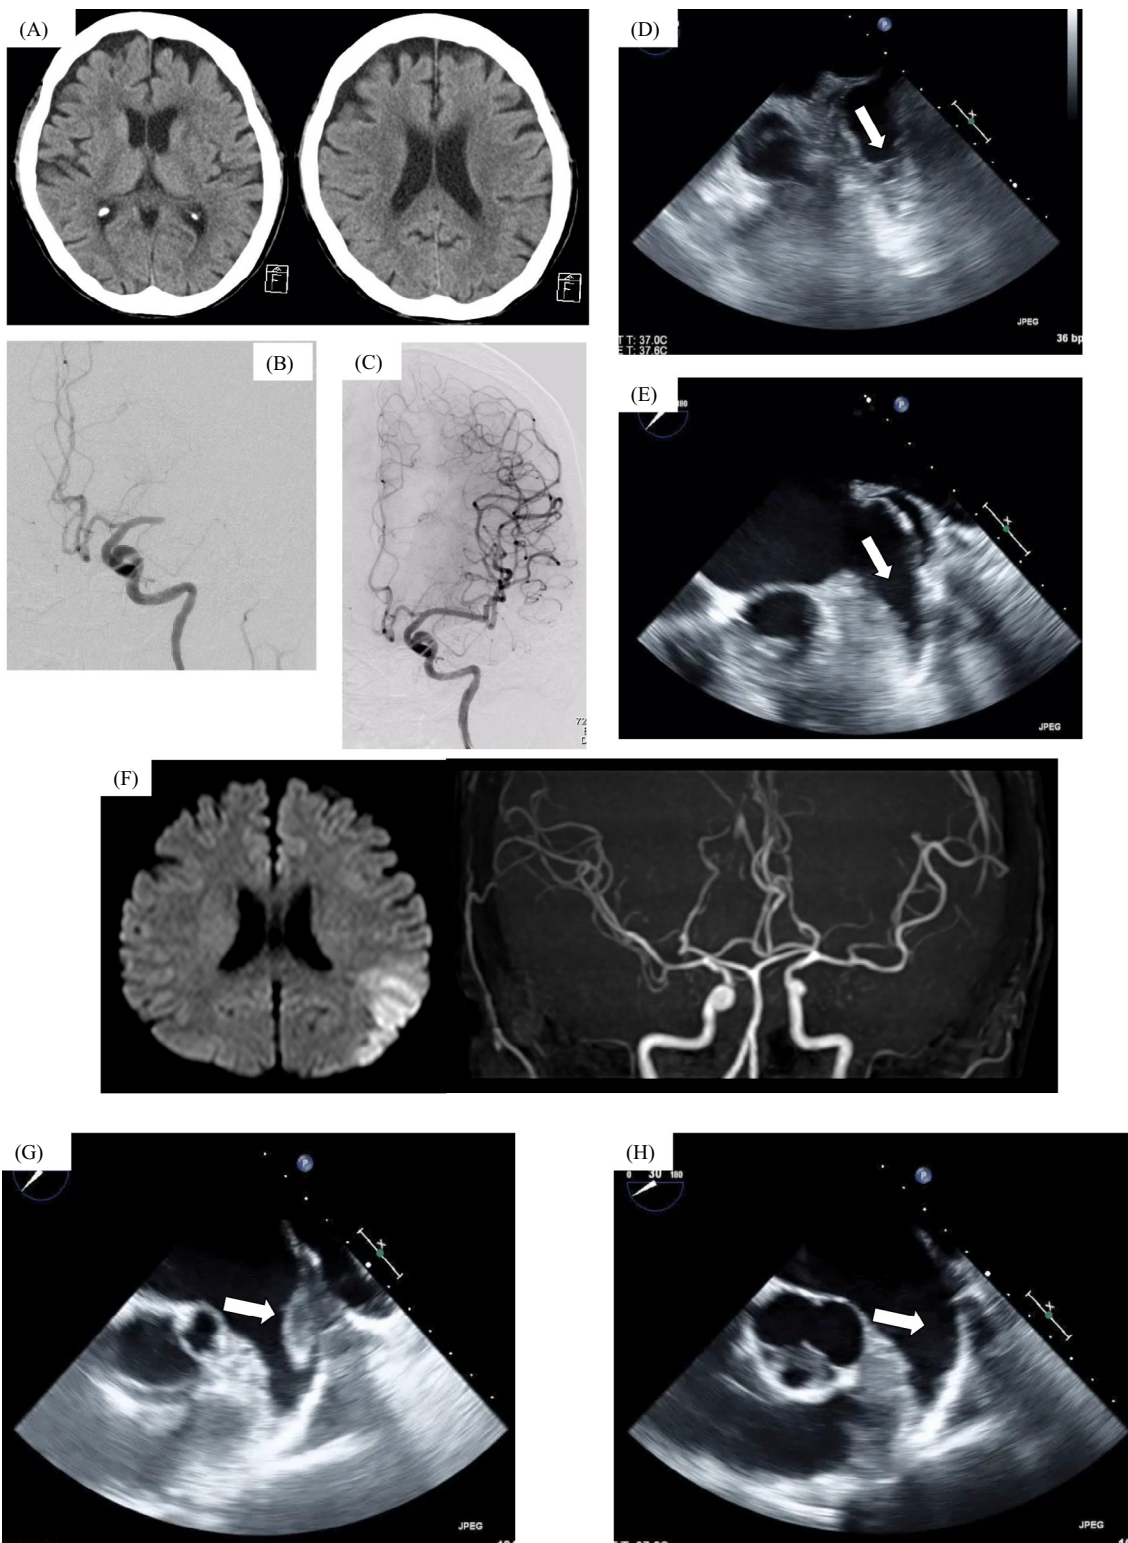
Images in case 1 (A–E) and case 2 (F–H). (A) Head computed tomography showed no early ischemic change in the left cerebral cortex. (B) Digital subtraction angiography showed the left middle cerebral artery occlusion. (C) Mechanical thrombectomy was performed and complete reperfusion was obtained. (D) A thrombus (arrow, 13.3×10.6 mm) in the left atrial appendage (LAA) detected on transesophageal echocardiography (TEE) performed on day 1. (E) Disappeared thrombus by TEE on day 13 after edoxaban therapy. (F) Brain diffusion-weighted magnetic resonance image showed hyperintense signal in the left cerebral cortex. Cerebral artery occlusion was not clear on magnetic resonance angiography. (G) TEE revealed a mobile thrombus (arrow, 27.5×15.0 mm) in the LAA on day 4. (H) Resolved thrombus by TEE on day 16 after edoxaban therapy.
